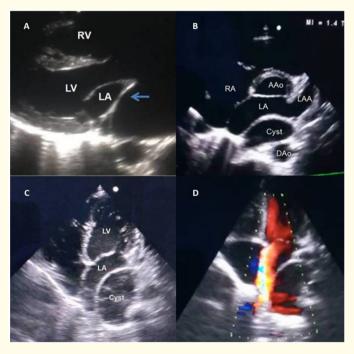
Transthoracic echocardiogram A - Parasternal long axis view showing a membranous structure dividing the left atrium (blue arrow). B - Parasternal short axis view showing a cystic image behind the left atrium. C - Apical four chamber view showing an extracardiac cystic mass D - Color Doppler suggestive of compression of the right pulmonary vein. AAo-Ascending aorta; DAo- Descending aorta; LA- Left atrium, LAA Left atrial appendage; LV-Left ventricle; RA-Right atrium RV-Right ventricle.
